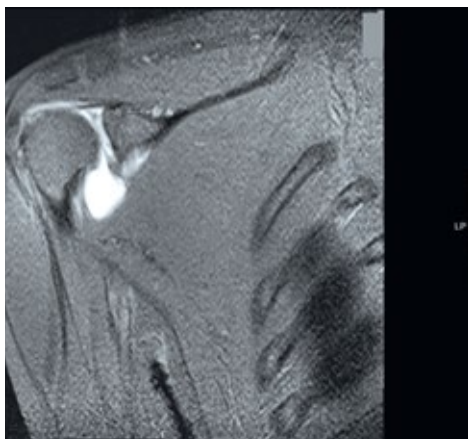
Example of a SLAP lesion type 5 (arrow) (oblique coronal orientation, T1-weighted): labrum lesion continues from anterior-inferior to anterior-superior and superior-posterior
